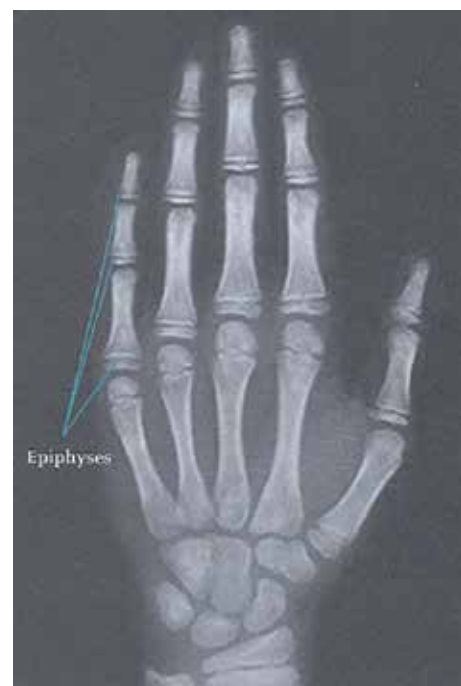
Bone age x-ray.
